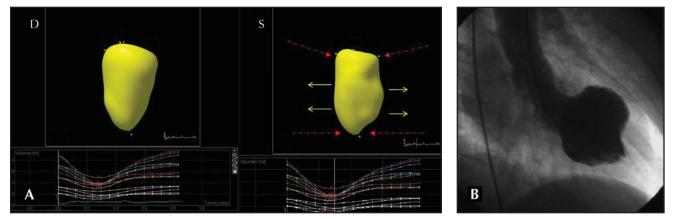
A, Three-dimensional echocardiography, showing left ventricular cavity at end-diastole (*D*), and end-systole (*S*). *Yellow arrows* show noncontracting middle segments, and *red arrows* show normal contracting apical and basal segments. B, Right anterior oblique ventriculography at end-systole. Note the normal contraction of apex and basal left ventricle.
